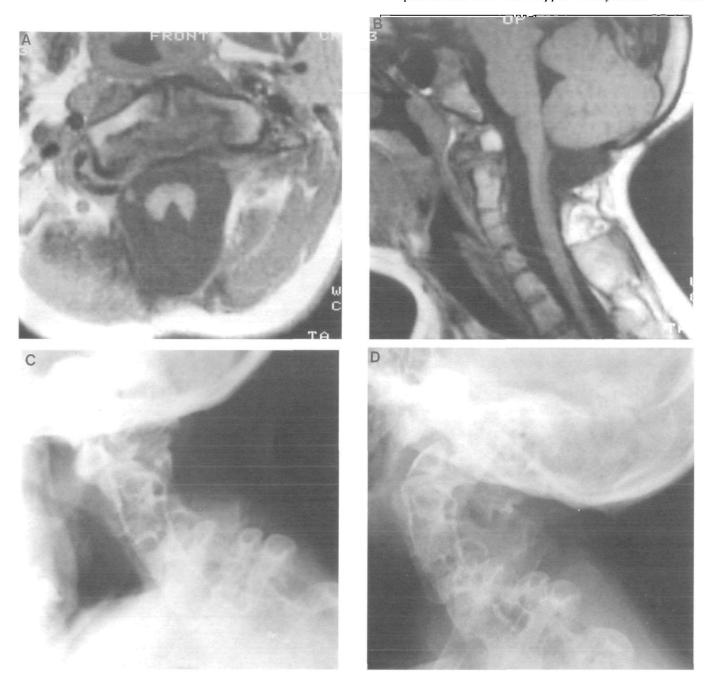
Case 5. (A) Axial MRI (T1 weighted image) showing partial dorsal wedge-shaped splitting of the upper cervical cord. (B) sagittal MRI (T_1 -weighted image) showing wide canal, vertebral fusion and os odontoideum. Extensive fusion and instability at C1/2 is demonstrated on (C) flexion and (D) extension lateral roentgenograms.
